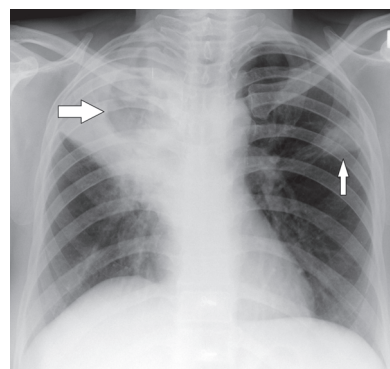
Chest radiograph in PA projection shows right upper lobe consolidation-collapse with cavitation (thick arrow) and subsegmental patchy pneumonitis in left upper lobe (thin arrow) in a case of progressive tubercular pneumonia.
